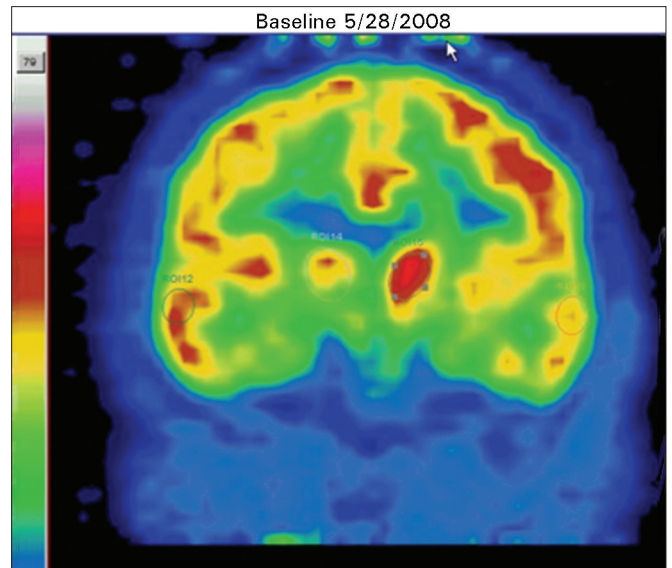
5/28/09 baseline FDG PET scan in coronal orientation identified bilateral medial temporal lobe hypometabolism, mildly increased right primary auditory cortex activity (ROI 12), decreased activity right thalamus (ROI 14) and right frontal, at a level of severe tinnitus.
